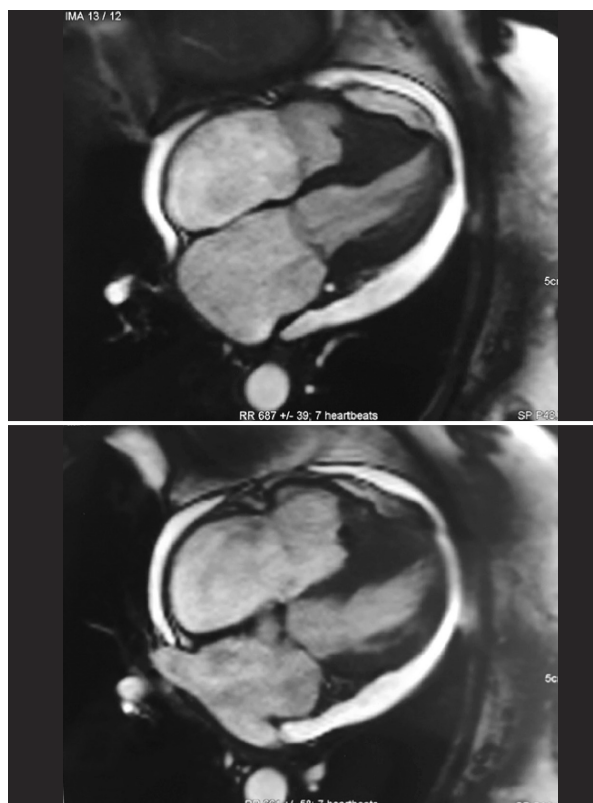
Cardiac MRI shows obliteration of the right ventricular apex and significant enlargement of the right atrium.
